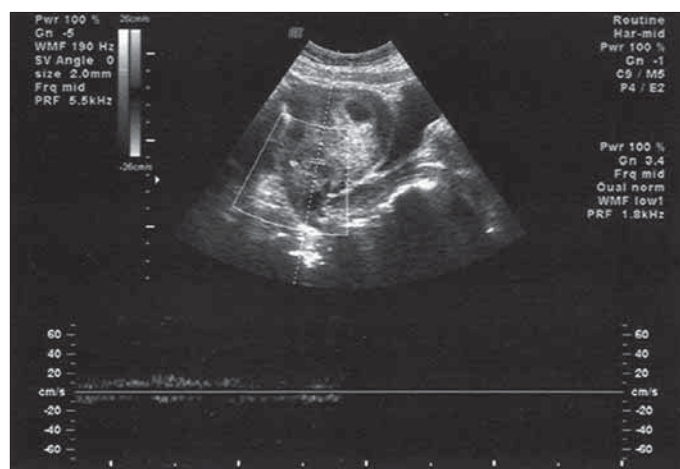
Torsioned ovary with no blood flow on Doppler US
